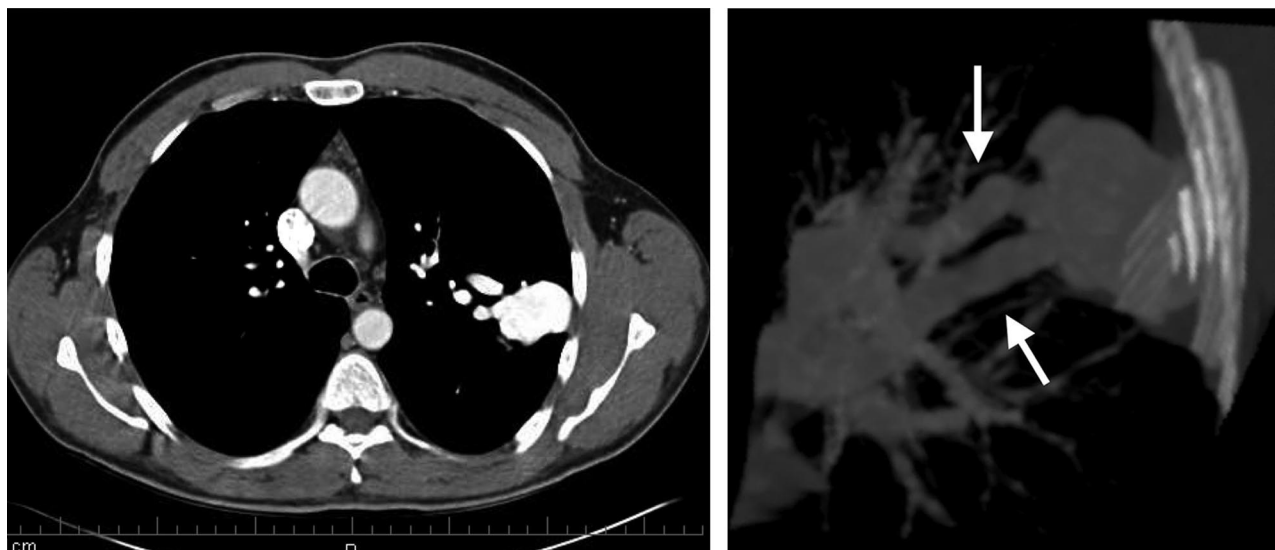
Left: Contrast computed tomogram shows an intensely enhanced left-upper-lobe mass. There are at least 2 dilated pulmonary vessels close to the mass. Right: Reconstructed image from the computed tomogram, with maximum intensity projection, shows the pulmonary arteriovenous malformation with the feeding and draining pulmonary vessels (arrows).
